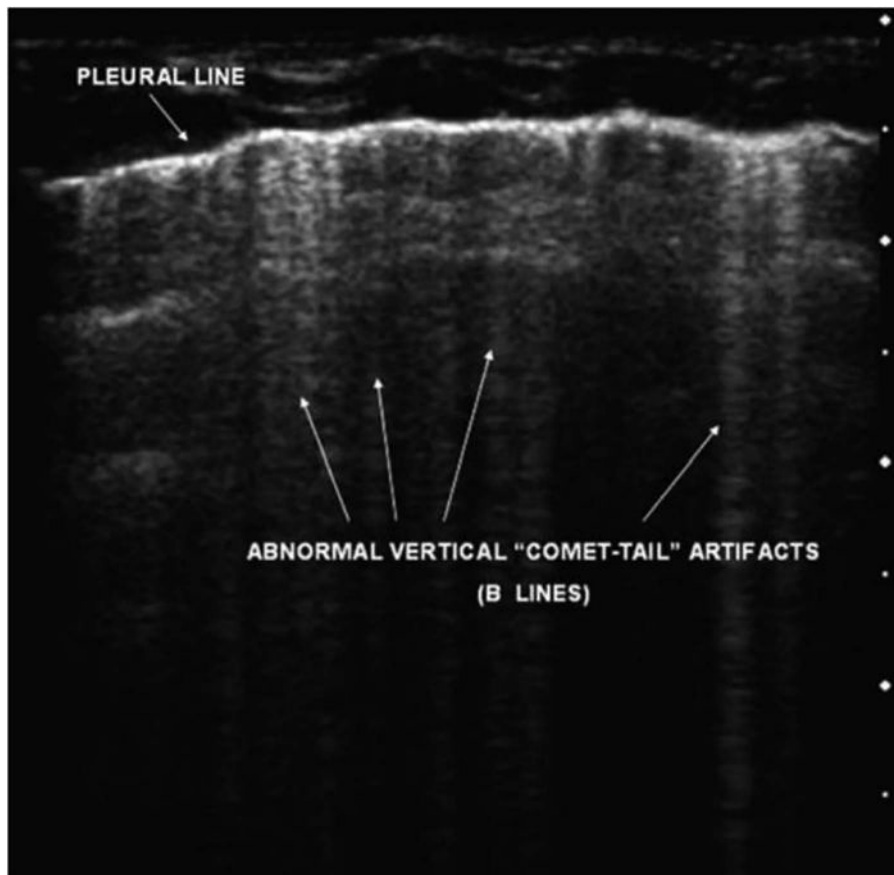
An ultrasound image of the thorax using a linear probe. The B lines are vertical bright lines that extend from the pleural line down to the bottom of the screen, indicating interstitial fluid in the lung (figure courtesy of Serpil Ozgen).
